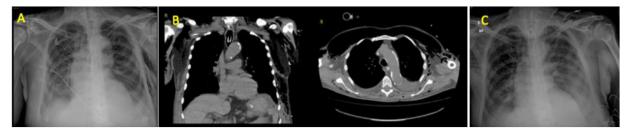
A. Chest radiograph showing subcutaneous emphysema of the left axilla after removal of the left chest tube. B. Thoracic computed tomography scan showing extended subcutaneous emphysema, after 4 days of conservative treatment of subcutaneous emphysema secondary to using a left chest tube. C. Chest radiograph: Subcutaneous resolution of the emphysema after 5 days of negative pressure therapy at -150 mmHg.
